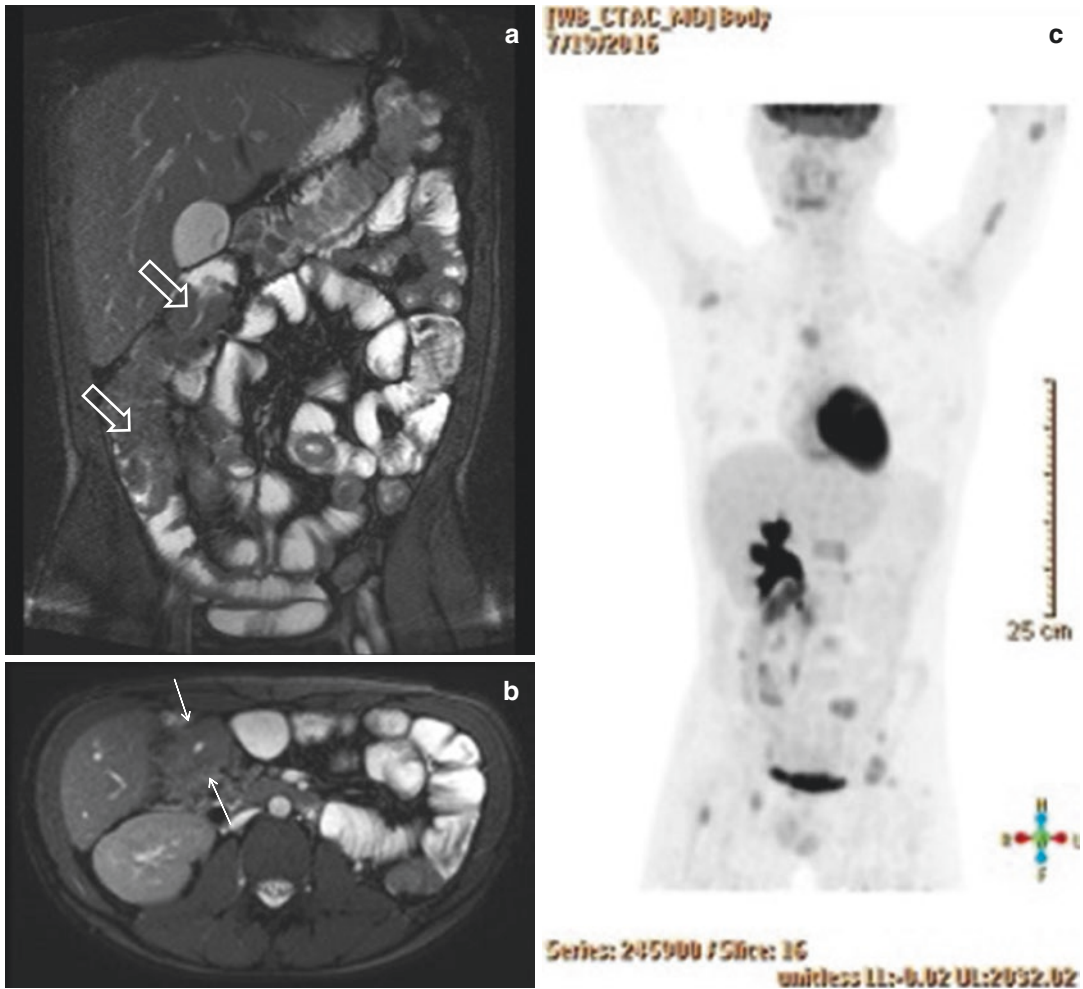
This 16-year-old boy was referred for suspicion of IBD. He had a history of bowel movement changes, abdominal pain, and a weight loss of 17 kg in a period of 8 weeks. Coronal (a) and axial (b) T2-weighted
